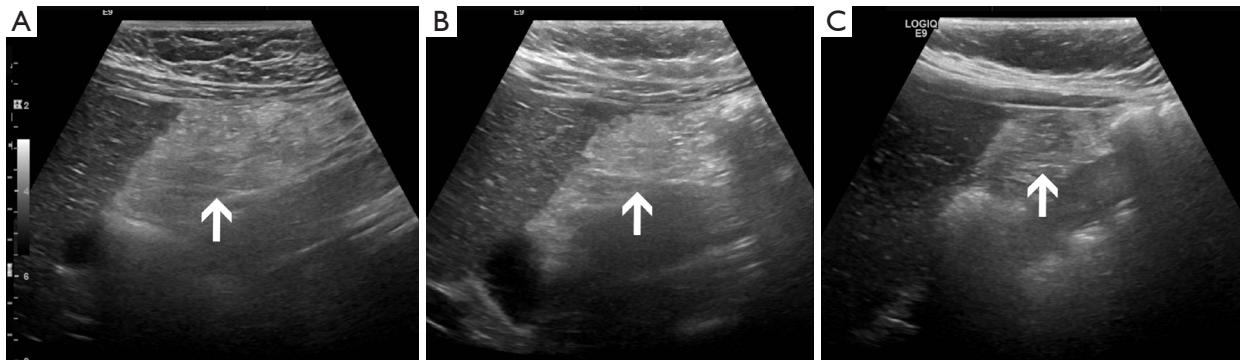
B-mode examination in omental infarction (A) and sonographic follow-ups after 15 (B) and 30 (C) days. The hyperechoic, incompressible, oval mass (arrows) showed a progressive reduction in size and echogenicity after conservative treatment. B-mode, brightness mode.
